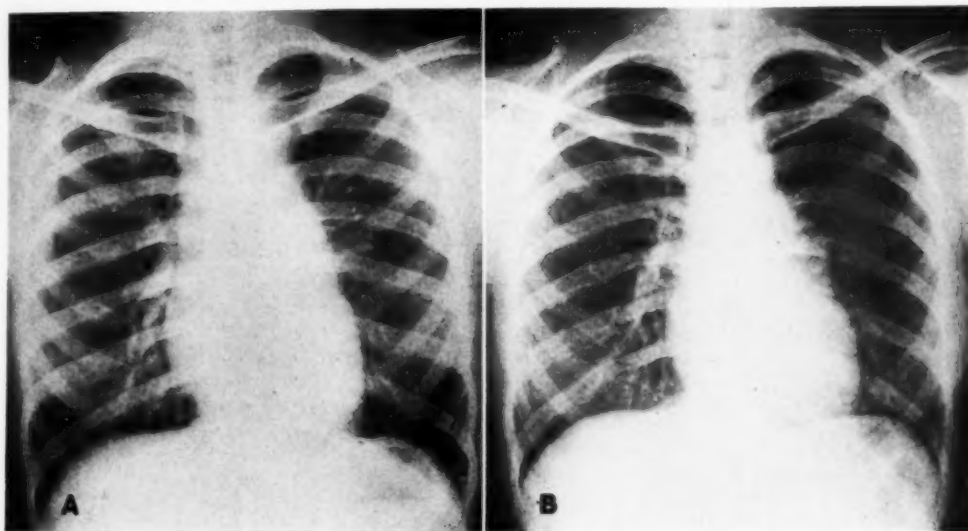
Case 10. A. Malignant thymoma before x-ray therapy. B. After treatment with 3,000 r of high-voltage x-rays.
